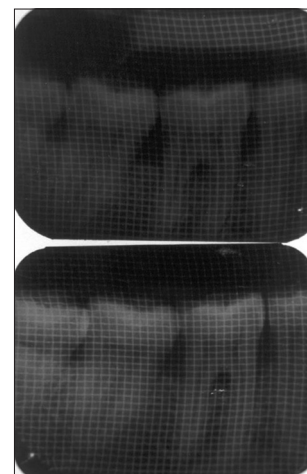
Pre and post x-rays showing bone level changes in the molar area
